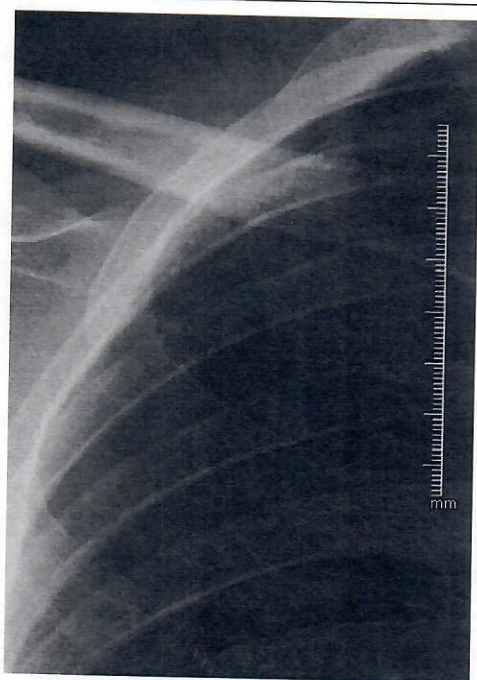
The pneumothorax was fully recovered without any intervention on the third day. There is no pneumothorax line on chest roentgenography.
